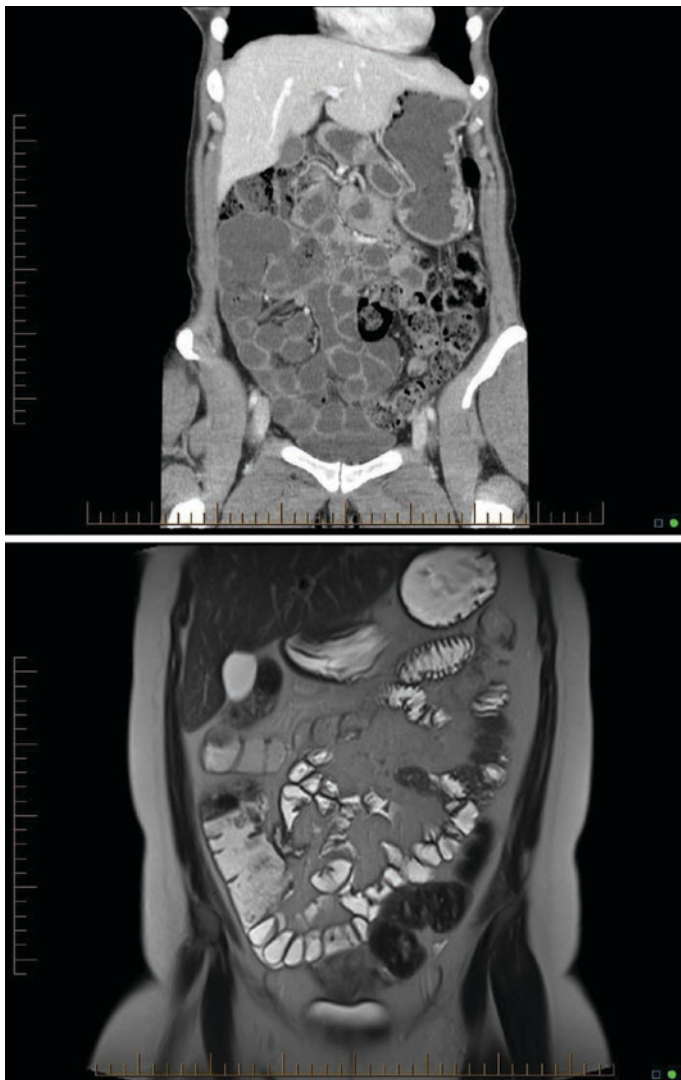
Normal CT and MR enterogram (coronal orientation)
